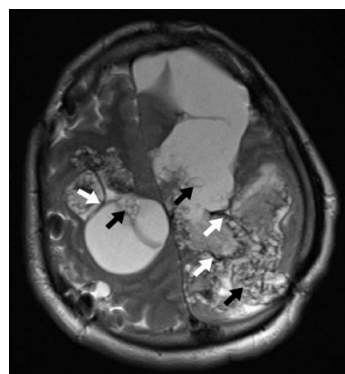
MRI of the brain in T2 view and cross section with bilateral cysts (black arrow) and wavy signal around them (white arrow)
